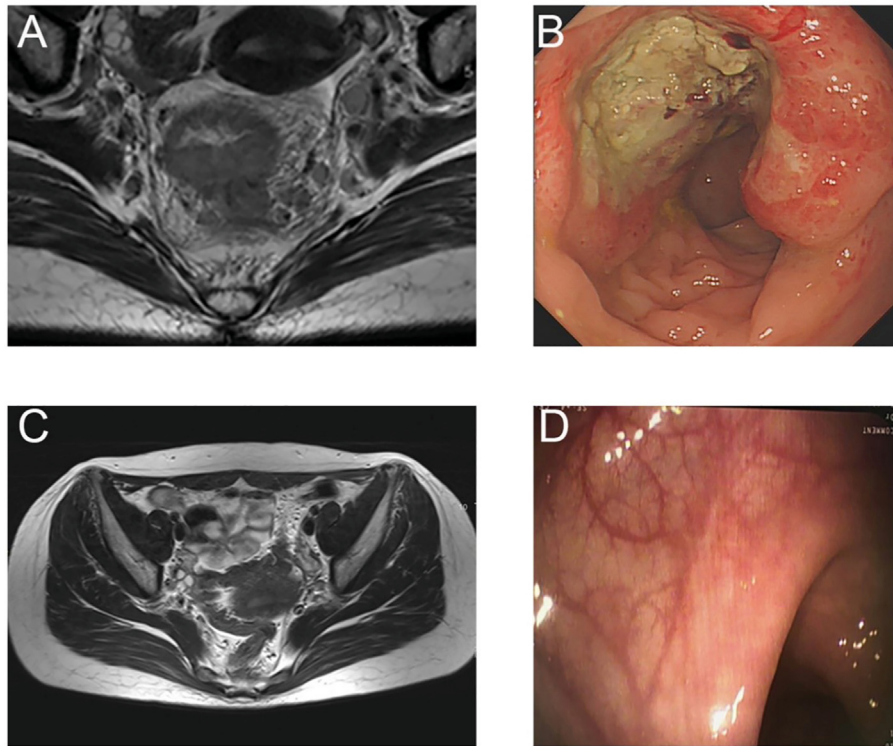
Representative MRI and colonoscopy images of Case 2. The representative MRI and colonoscopy images of the patient showing a mass in the rectum (A and B) at diagnosis and cCR (C and D) after anti-PD-1 immunotherapy.
